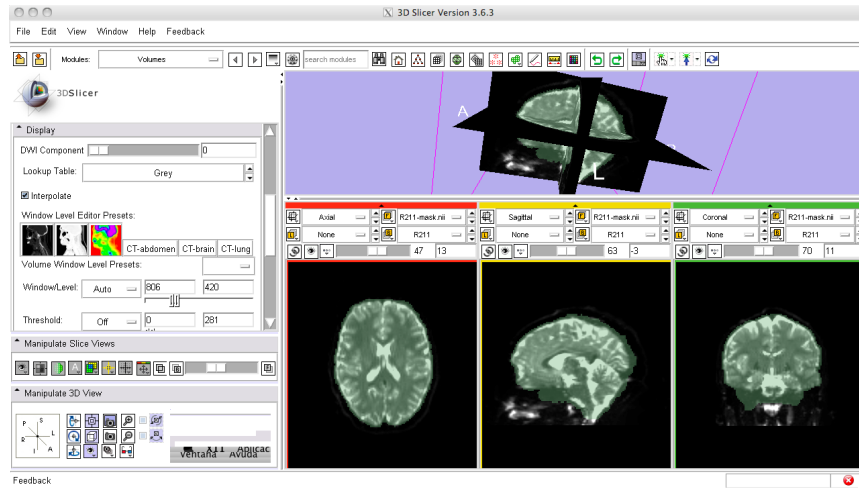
Input HARDI-DWI volume with the ROI superimposed.
